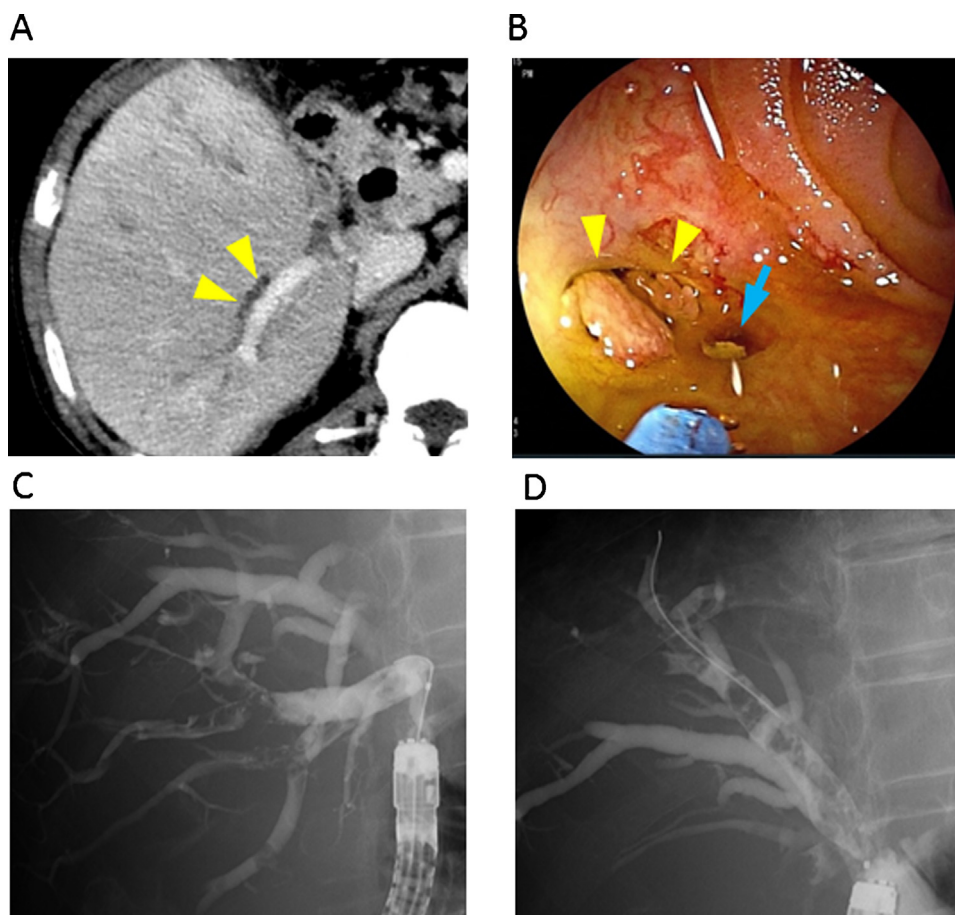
(A) Postoperative CE-CT imaging study: Arrowheads indicate dilatation of the intrahepatic duct of the posterior segment. (B–D) Postoperative imaging studies using double-balloon enteroscopy (DBE): (B) Arrowheads and arrow indicate the papillary tumors protruding from the anastomotic orifice of hepatic duct of segment 6 (B6) and segment 7 (B7), respectively. DBE-assisted direct cholangiography indicates filling defects throughout B6 (C) and B7 (D).
